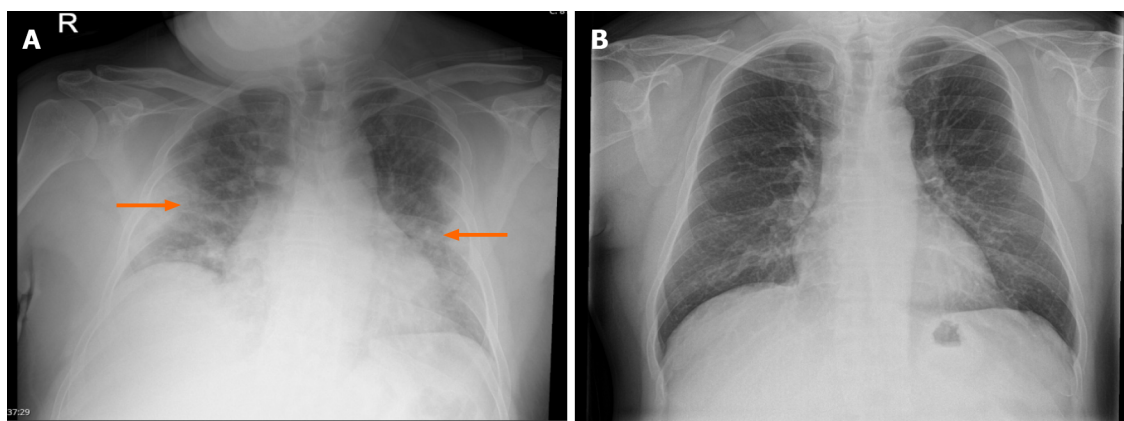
Case 1. A: Chest radiograph (CXR) at the time of admission showing bilateral extensive airspace opacities (arrows); B: The CXR at 8 wk showing complete resolution of pulmonary opacities.
